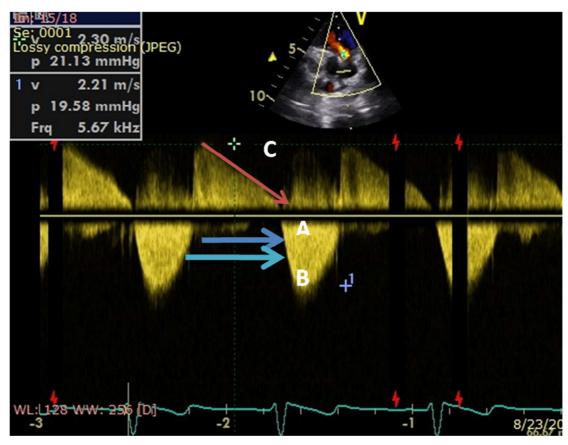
The figure shows CW Doppler of the PV flow, [A] represents the measurement of the duration of the PR signal, [B] represents the total duration of diastole, and [C] represents the measurement of the deceleration time of the PR spectral Doppler signal.
